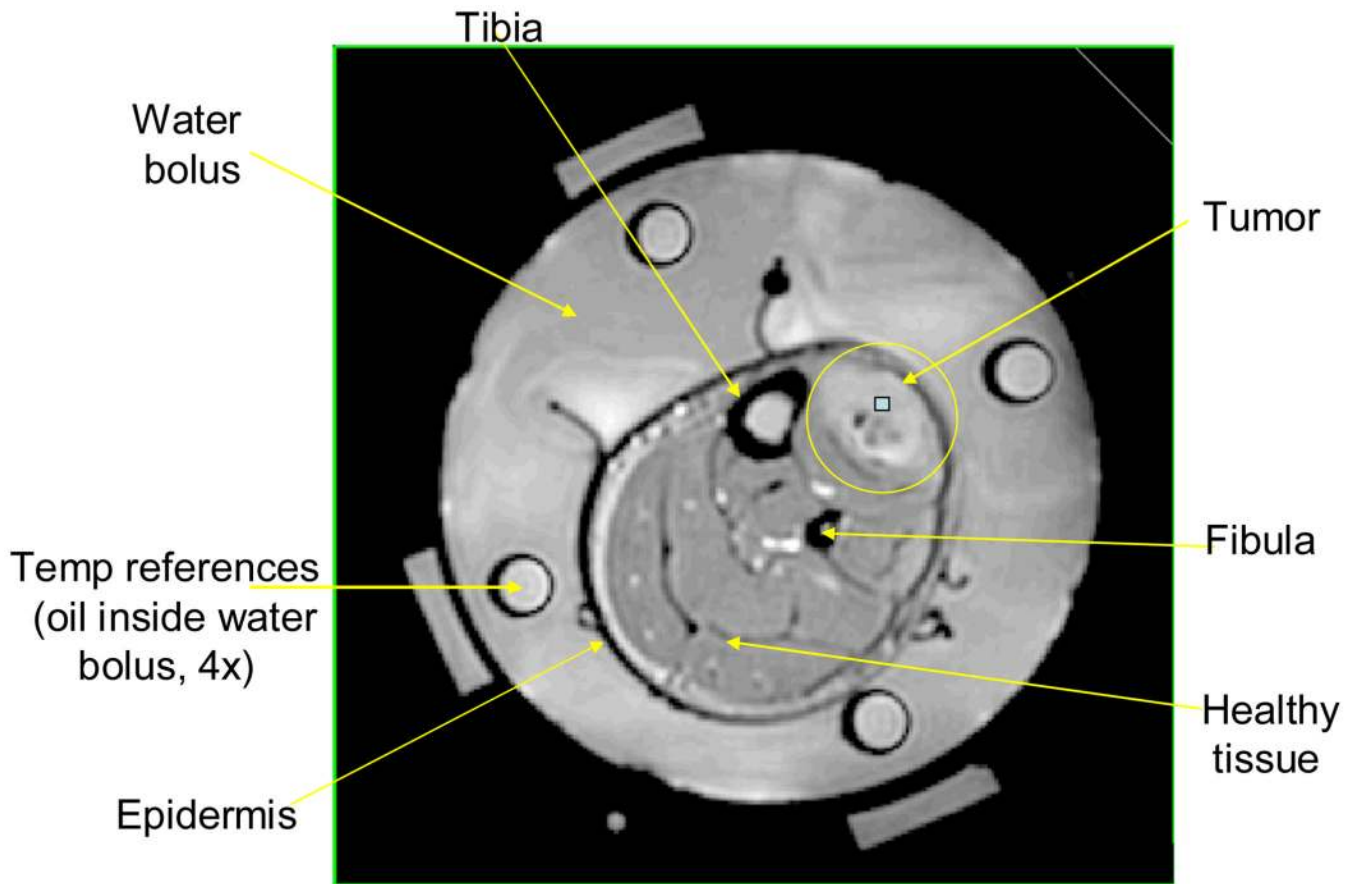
MRI cross-section of patient's lower leg inside 4 antenna MAPA applicator.
